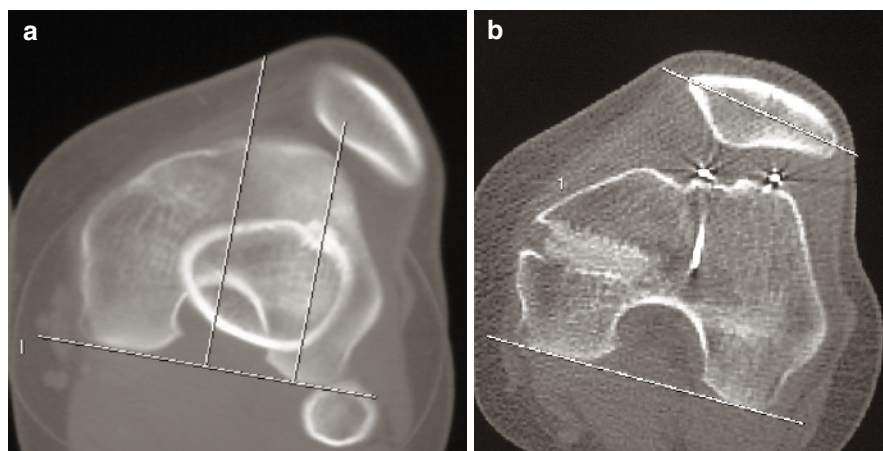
(a) Pre-operative CT scan shows excessive TT-TG and pathological patellar tilt. (b) CT scan of the same patient after trochleoplasty shows the correction of the patellar tilt, the two staples, and the blind tunnel
